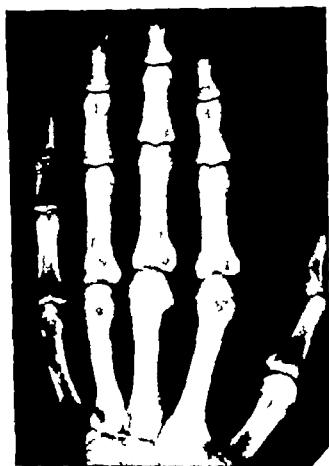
Roentgenogram of a hand showing multiple sharply punched-out, rarefied defects in the third and fifth fingers reflecting the presence of hemangio-endotheliomas. (The largest one in the distal phalanx of the fifth finger was biopsied.) The patient also presented a small hemangio-endothelioma in the subcutaneous tissue of the wrist.
